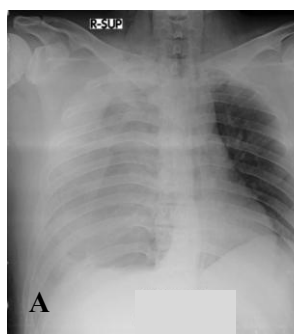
A, X-ray of the thorax showed hemothorax on the right lungs; B, three days after, pleural effusion on the right lungs with chest tube
